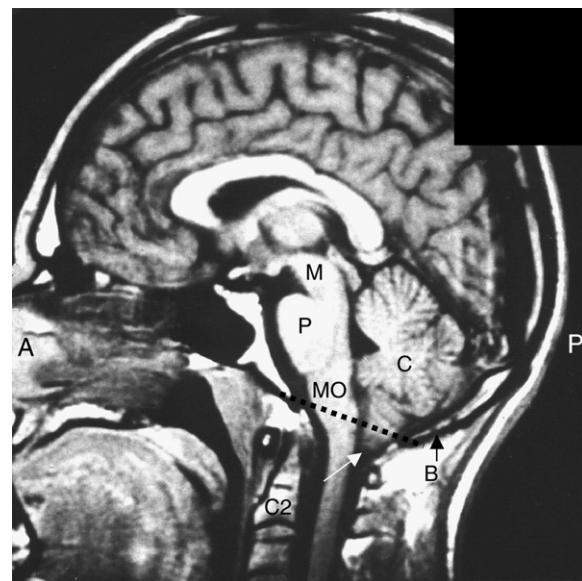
Brain MRI sagittal T1-weighted image (approximately centrally through the brain) showing the mild projection of the cerebellar tonsil(s) (cerebellar ectopia) (white arrow) through the foramen magnum, i.e. as a mild Chiari I malformation. This malformation projects below the level of the foramen magnum that is represented by the broken black line across that region. A = anterior; P = posterior; C = cerebellum; B = occipital bone at the back of the skull; C2 = second vertebral body; M = midbrain; MO = medulla oblongata; P = pons. Note how the cerebellum, pons and medulla oblongata are contained within the *posterior cranial fossa* and that the *brain stem* comprises the midbrain, the pons and the medulla oblongata and connects the cerebral hemispheres with the spinal cord.
